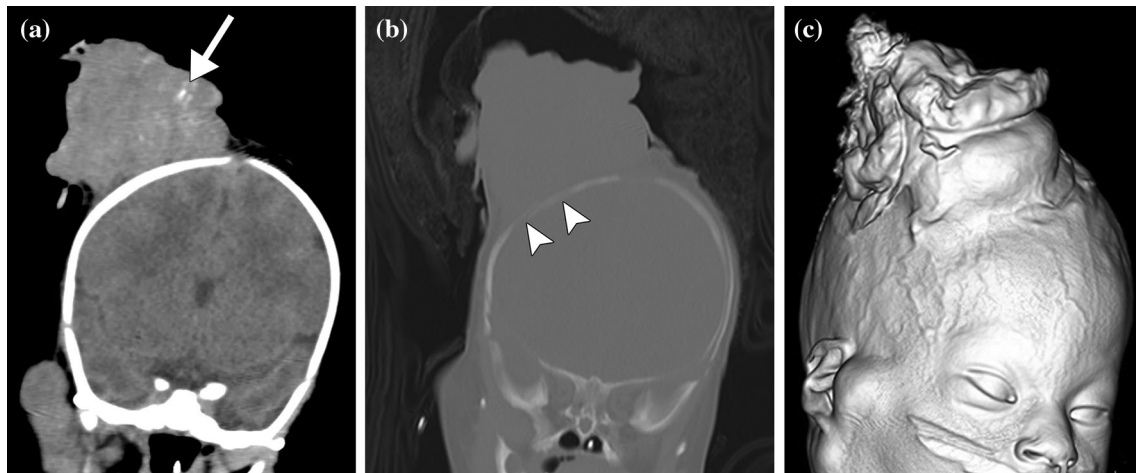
Coronal soft tissue window (a), coronal bone window (b), and 3D (c) CT images show bulky right scalp and pre-auricular tumors with intratumoral hemorrhage (*arrow*) and osseous erosions (*arrowheads*) associated with right scalp mass
